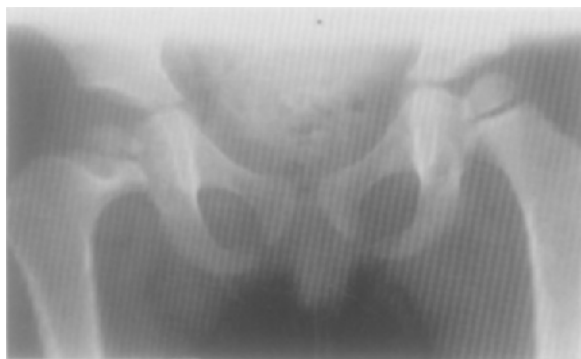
Girl born 16/5 1965. Reduction under anaesthesia 1/9 1965. Immobilized in plaster for 3 months. X-ray picture above at the age of $1\frac{1}{2}$ year.
